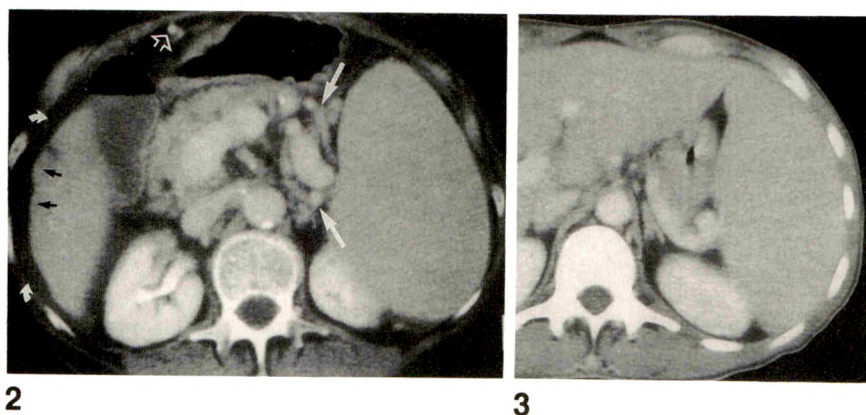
Cirrhosis. CT scan shows enlarged spleen with homogeneous parenchyma, a manifestation of portal hypertension. Also, note large splenic hilar varices (straight solid white arrows), recanalized periumbilical vein (open arrow), nodular liver edge (black arrows), and ascites (curved arrows).
